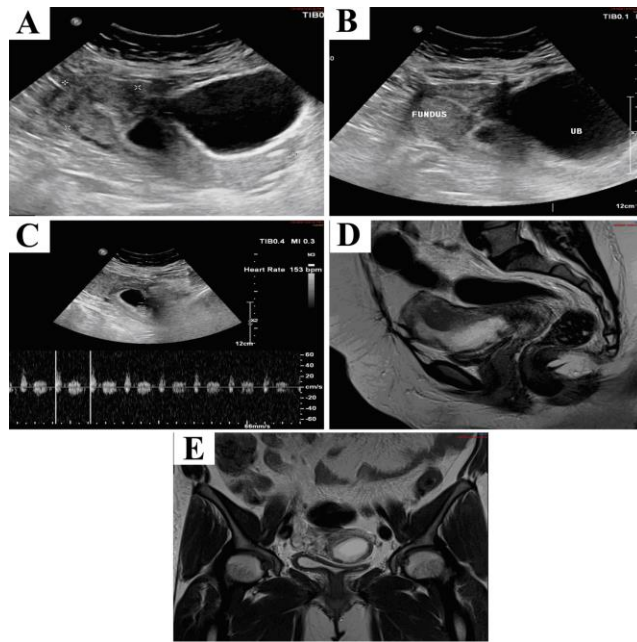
A and B; the pelvic US revealed low positioning of the intrauterine gestational sac with a 3 cm distance from the fundal endometrium. C; viable fetal pole with 180 beats per minute fetal heart rate. Questionable UB invasion is suspected by the US so, further MRI has been done. D; sagittal, E; axial, F; coronal T2WI confirmed the presence of CSP with thinning of the anterior myometrial wall, however, excluded the presence of any UB invasion.
